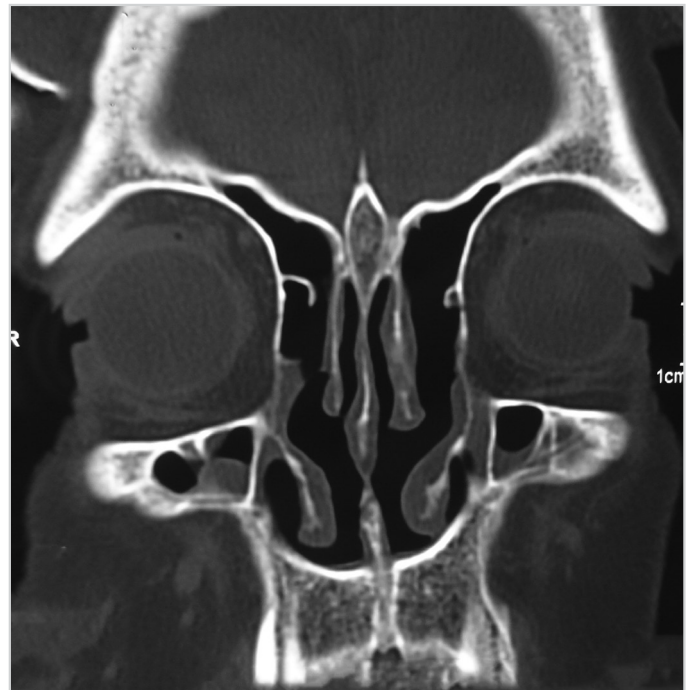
Control PNS CT in the 4<sup>th</sup> postoperative month
